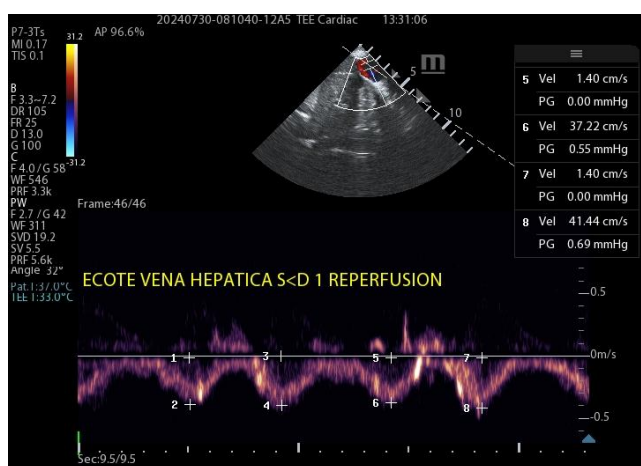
Hepatic Vein Doppler at reperfusion in the kidney transplant patient.
